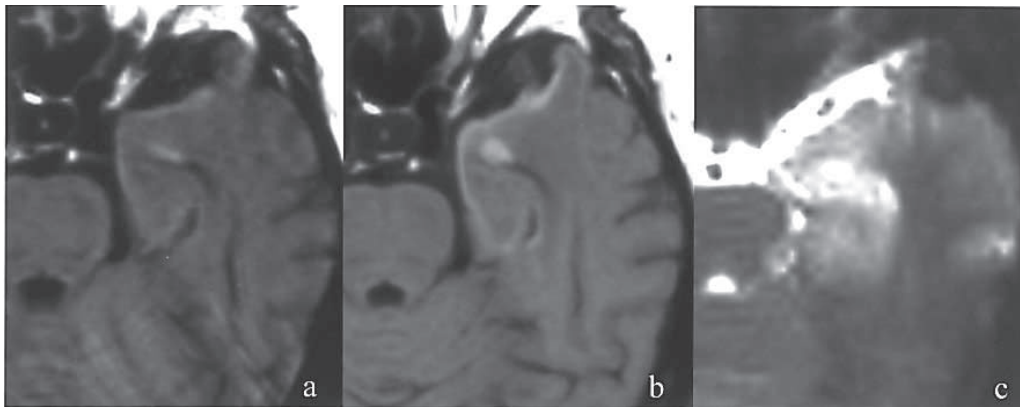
(a) Enhanced T1-weighted image at 21 days showed curvilinear enhancement along the cortices of left medial temporal lobe. (b) The enhancing areas on the enhanced T1-weighted images at 21 days well corresponded to the areas of the curvilinear hyperintense signals along the left medial temporal cortices observed on unenhanced T1-weighted images at 35 days. (c) T2*-weighted gradient-echo image demonstrated no signal decrease around the areas of curvilinear hyperintense signals along the cerebral cortices observed on unenhanced T1-weighted image.
